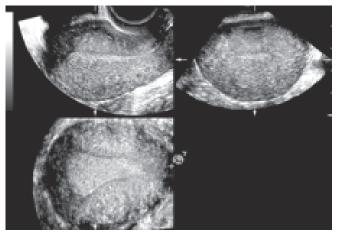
Three-dimensional ultrasound image of normal uterine cavity
